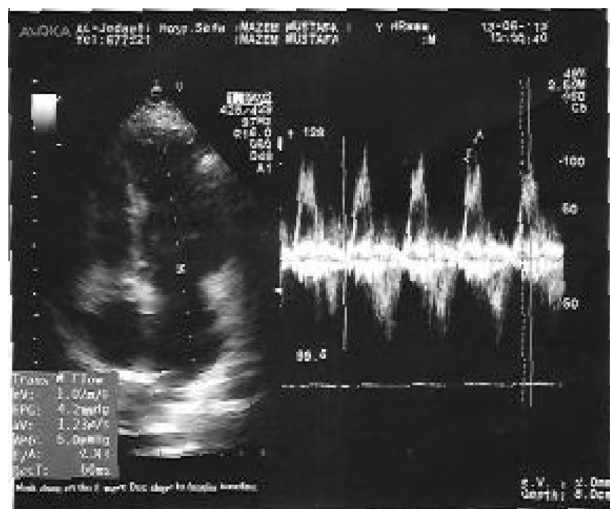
Doppler echocardiography showing reversed E/A ratio of the mitral valve flow.
